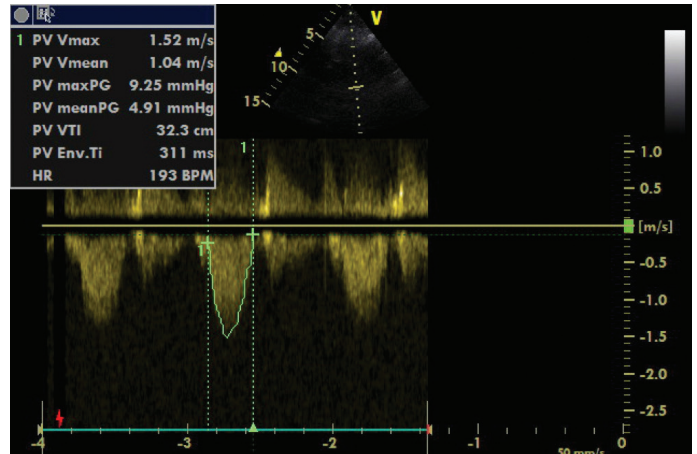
2nd year control of pulmonary gradient. In the 2nd year control echocardiography; Pv max was measured 1.52 m/s and pulmonary max gradient 9.25 mmHg.
